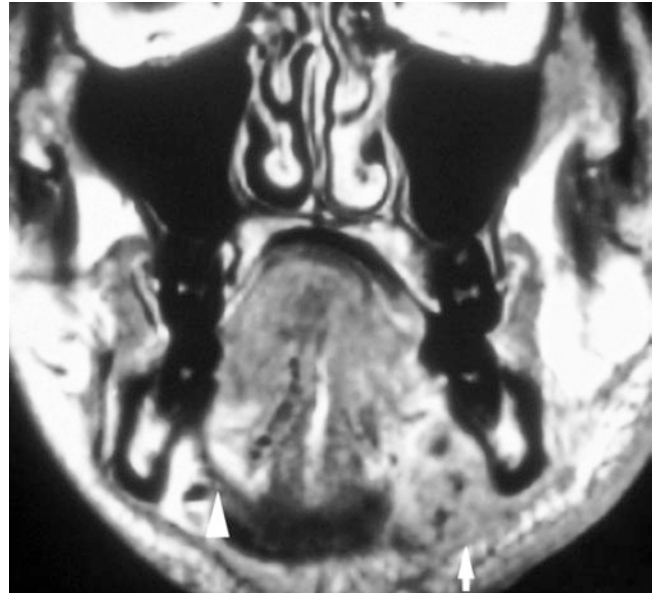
Squamous cell carcinoma of the tongue invading the floor of the mouth; 22-year-old male with history of tongue cancer, now with recurrence. Coronal T1-weighted post-Gd MRI shows moderately contrast-enhanced tumor penetrating mylohyoid muscle and platysma (arrow). Note normal mylohyoid muscle on contralateral side (arrowhead)
